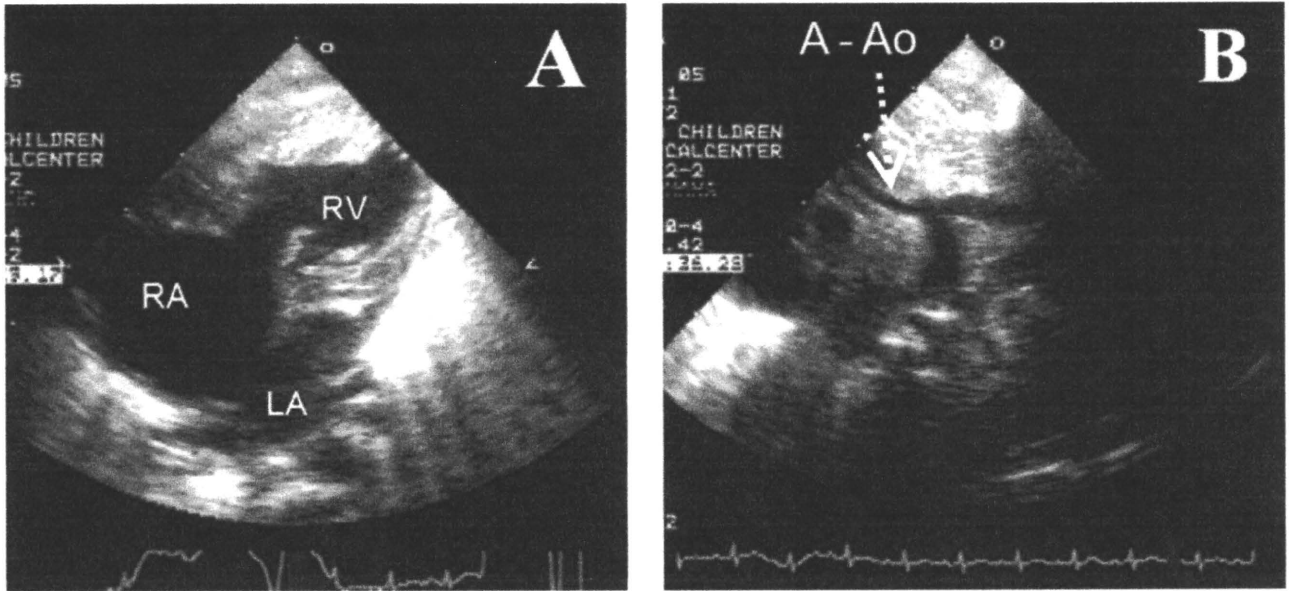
Echocardiographic image of the patient. (A) Apical four-chamber view. Note hypoplastic left ventricle. (B) Suprasternal sagittal view. Note narrow ascending aorta of less than 1.5 mm in diameter. A-Ao, ascending aorta; LA, left atrium; RA, right atrium; RV, right ventricle.
